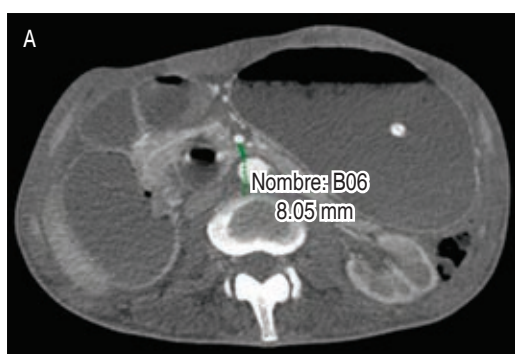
Contrast CT scan. A) Axial section showing a distance between the aorta and mesenteric artery of 8.05 mm. B) Coronal section showing gastric dilatation with loss of gastric folds and amputation of the third portion of the duodenum.
